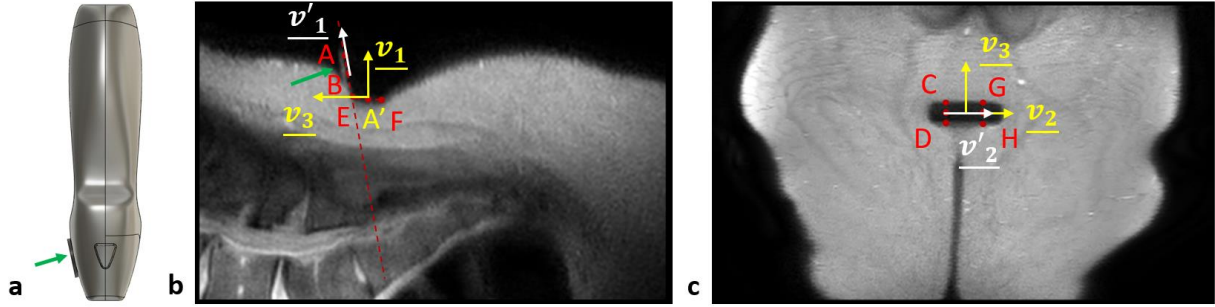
a) Sagittal view of the 3D printed indenter, green arrow points at the reflective marker; b) Sagittal slice, the red dotted line is aligned with the reflective marker; c) Frontal slice of the MR image.
